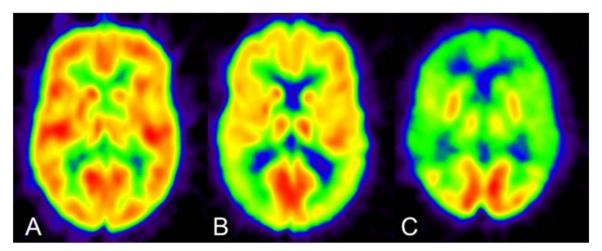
(A) FDG-PET of a cognitively normal subject; (B) of a patient with suspected early Alzheimer's Disease (C); and of a patient with advanced Alzheimer's disease. Expected distribution pattern of avid cortical FDG uptake on the grey matter, the basal ganglia, and the thalami is seen in the healthy subject. The patient with MCI demonstrates widespread obvious reduction in the parietal (more pronounced) and secondarily in the frontotemporal and basal ganglia glucose metabolism; the findings are worse on the right side. The regional cerebral metabolic rate of glucose is severely impaired on the patient with advanced Alzheimer's disease with residual tracer activity on the thalami and basal ganglia. The occipital cortex retains its physiological glucose metabolism in Alzheimer's disease, unlike in dementia with Lewy bodies.
